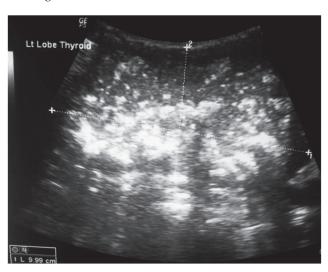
Thyroid ultrasound showing prominent multifocal calcifications in left lobe of thyroid gland.
